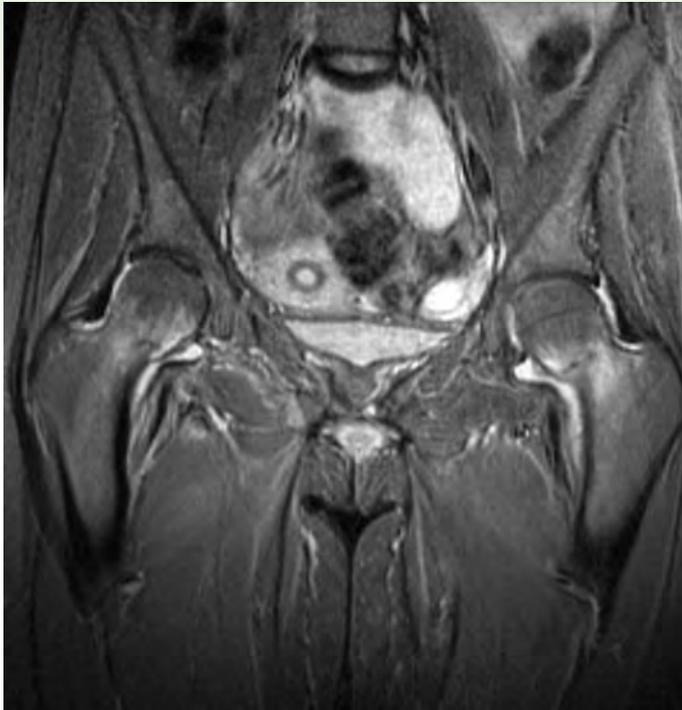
MRI demonstrating the bilateral fractured neck of femur.
